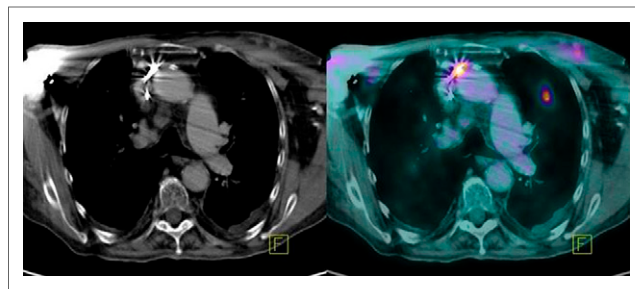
PET/CT images of case of pulmonary septic embolism.
